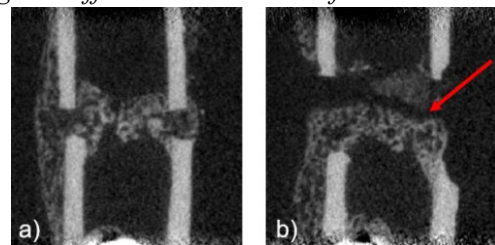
μ CT at Day 14: a) small gap, b) large gap; arrow indicates non-calcified tissue layer.
